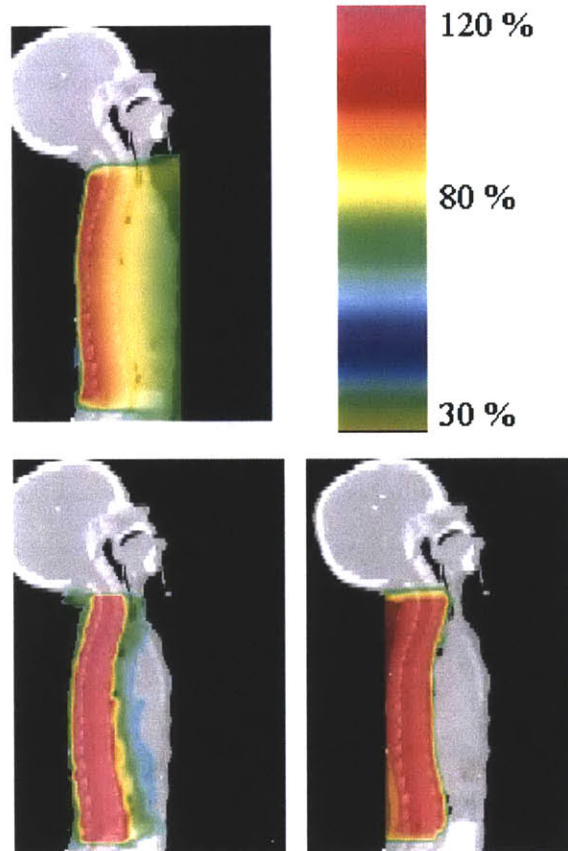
Dose distribution along the spinal column of a child treated with conventional X-rays (top left), IMRT (bottom left), and protons (bottom right). Significantly lower doses are delivered to the torso when treating with proton therapy compared to conventional x-rays and IMRT. [8]
